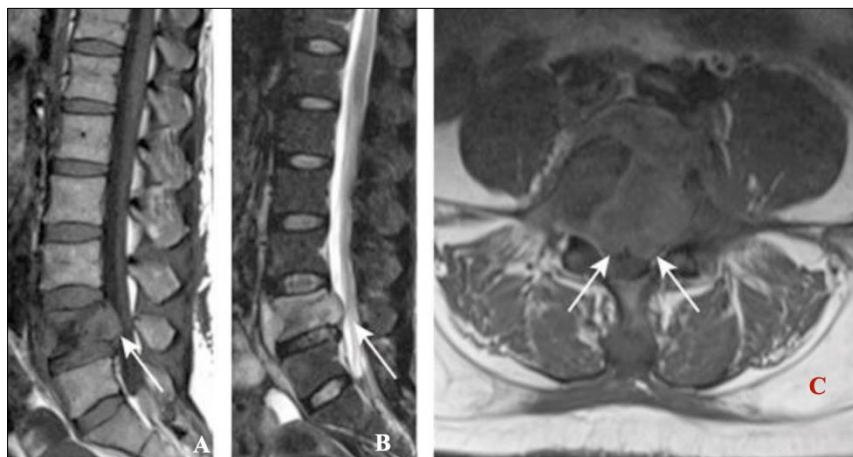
Thoracolumbar MRI showing a monofocal Pott's disease lesion at the L4 level A: Sagittal T1-weighted image B: STIR sequence C: Axial T1-weighted image
